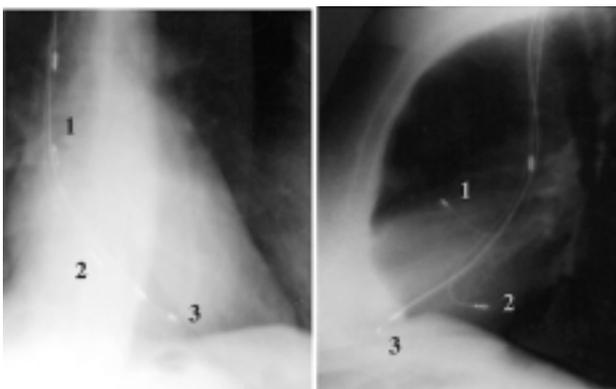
X-ray lead position for multisite atrial DDD pacing (left: antero-posterior view; right: latero-lateral view). 1 = bipolar J lead in the right auricle; 2 = screw-in unipolar lead at the ostium of the coronary sinus; 3 = bipolar right ventricular lead.
